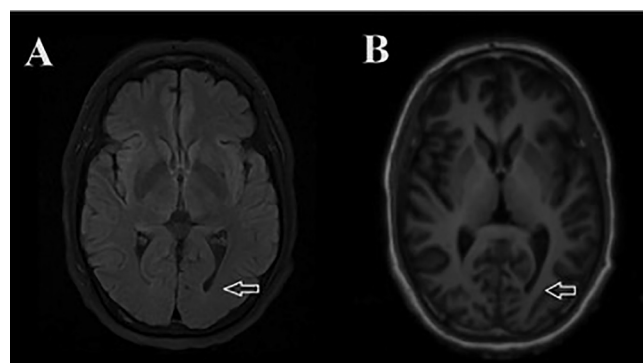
Out-pouching of right lateral ventricle as seen on A) T2 FLAIR and B) T1 MPR image sequences.
